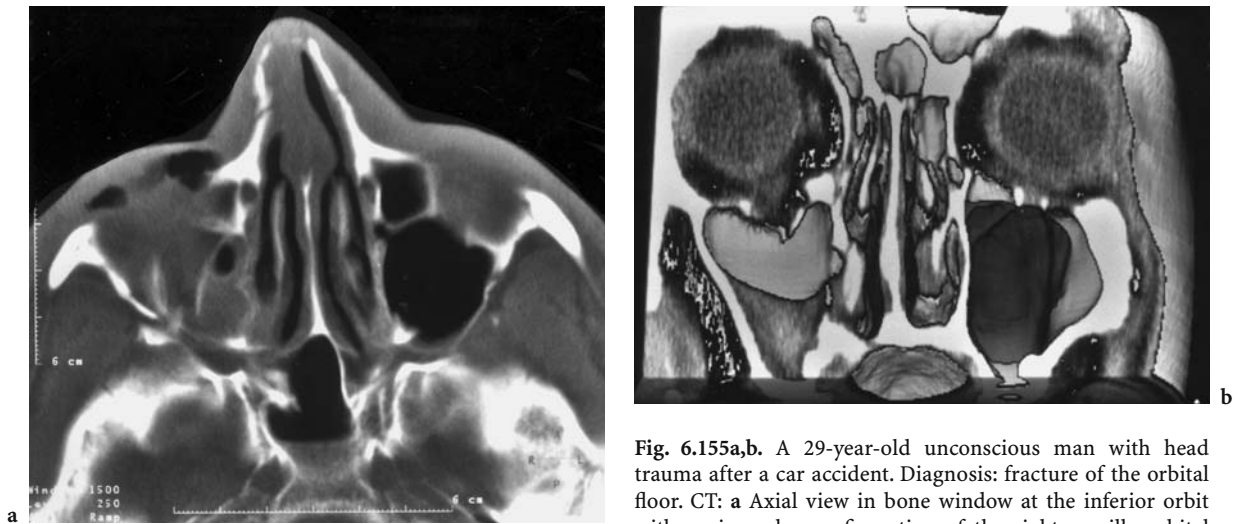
A 29-year-old unconscious man with head trauma after a car accident. Diagnosis: fracture of the orbital floor. CT: a Axial view in bone window at the inferior orbit with an irregular configuration of the right maxillo-orbital transition and subcutaneous air inclusion, in addition to a fractured ipsilateral nasal bone. b Corresponding 3D-reconstruction with superimposed soft tissue, demonstrating the extent of fragment dislocation
